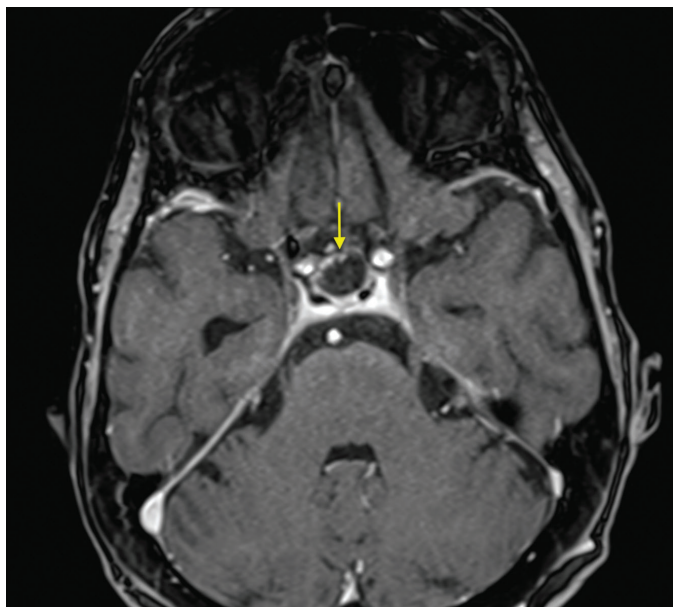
Magnetic Resonance Imaging: A) Axial section with hypo-intensive cystic structure in the pituitary region (T1WI), post-contrast increase in intensity only in the periphery of the cystic tumour with slight parasellar spreading and suprasellar extension on right side, indicated by arrow. B) In the coronal section (T2WI) with hyper-intensive signal in location of cyst, indicated by arrow.
